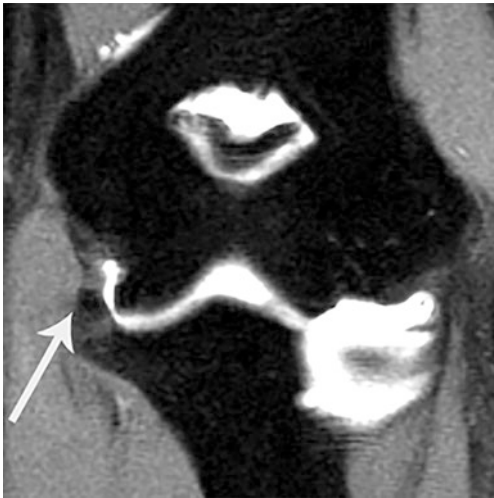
Coronal T1-weighted image demonstrates marked thickening of the anterior band of the UCL seen in chronic injuries (*arrow*)
